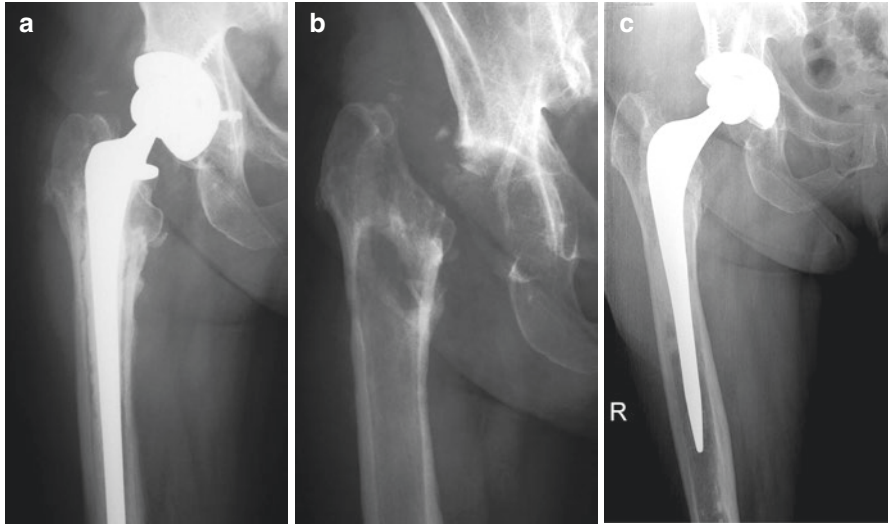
(a) Anteroposterior radiograph of a hip in a 72 year-old woman shows an infected cementless hip prosthesis. (b) Resection-arthroplasty. (c) Three months later, the hip was reconstructed using a cementless cup and impacting bone grafting with a cemented femoral long-stem showing a good outcome at 10 years
